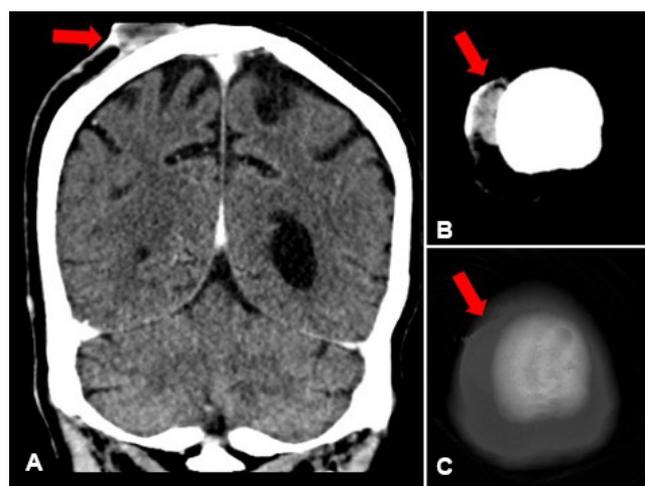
Computed tomography (CT) images of the brain. A and B: Postcontrast images of the extracranial, soft-tissue mass in right high parietal scalp region in coronal (A) and axial (B) views, respectively. C: Axial bone window view that corresponds to B shows no radiological evidence of bony involvement under the extracranial, soft-tissue scalp mass.
